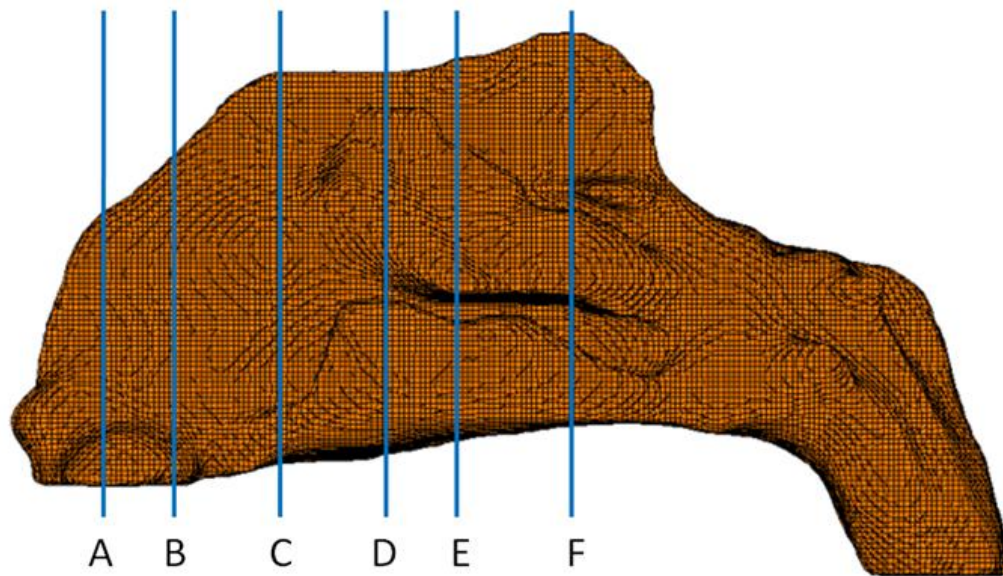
Trimmed cell mesh model was performed after constructing the 3D model obtained from CT images. Cross-sectional grid models in coronal and saggital planes are shown in this figure.
